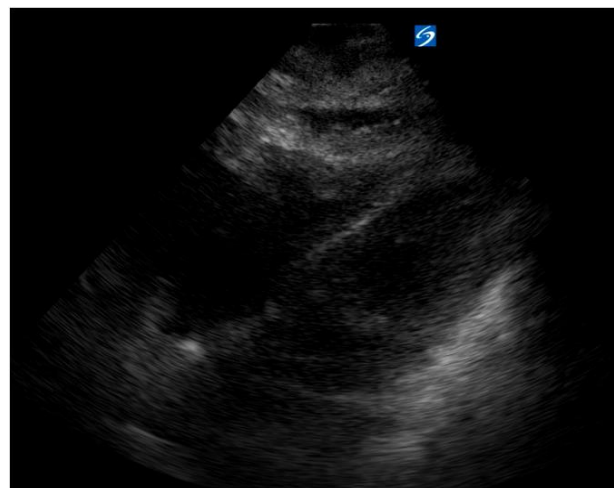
Pericardial effusion seen by ultrasound. Representative sub-xiphoid cardiac view, courtesy of Tom Carver, MD, as our case’s images never saved.
